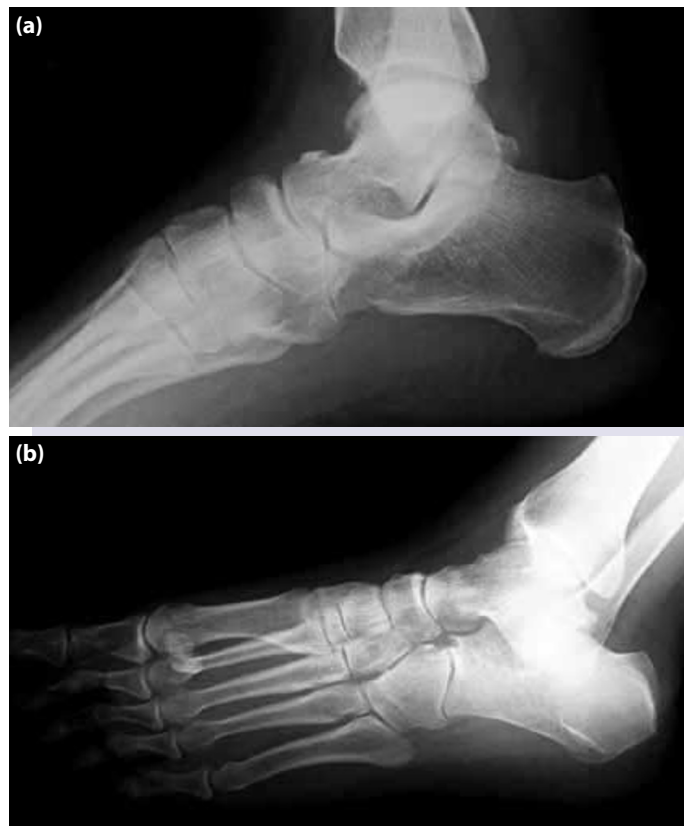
(a) Lateral and (b) oblique foot radiographs of the patient.
